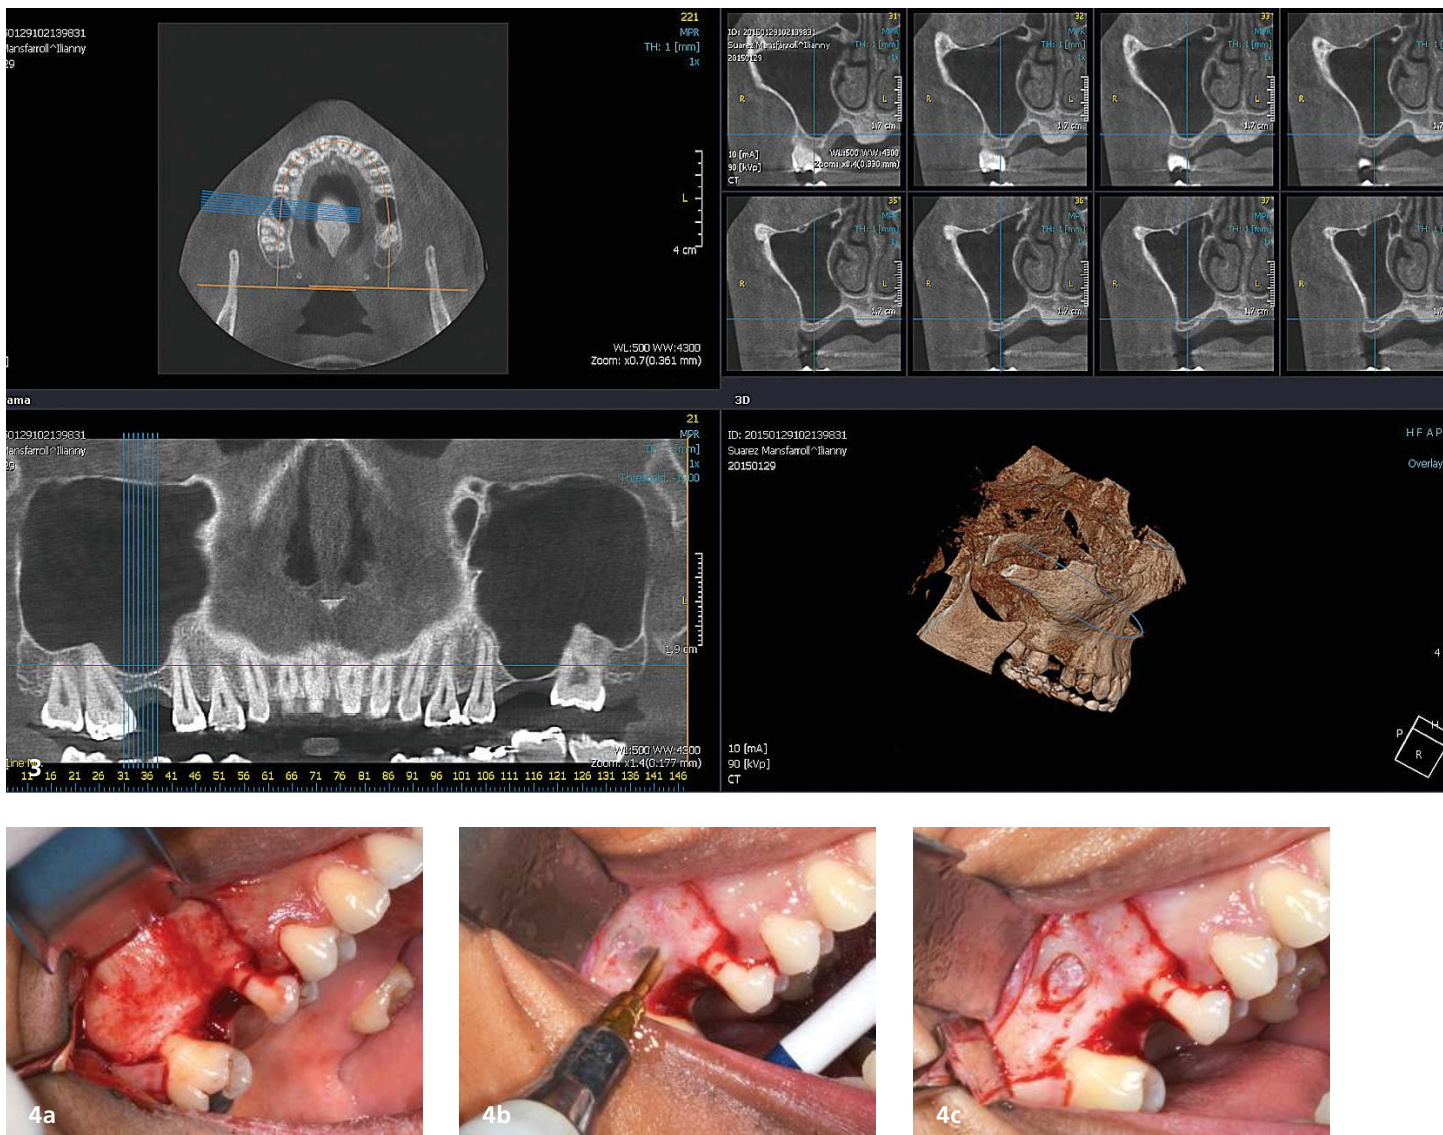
A CBCT scan was deemed necessary to determine the appropriate therapeutic approach. – Figs. 4a–c: Following mucoperiosteal flap elevation, a lateral window was prepared using the piezo technique.
